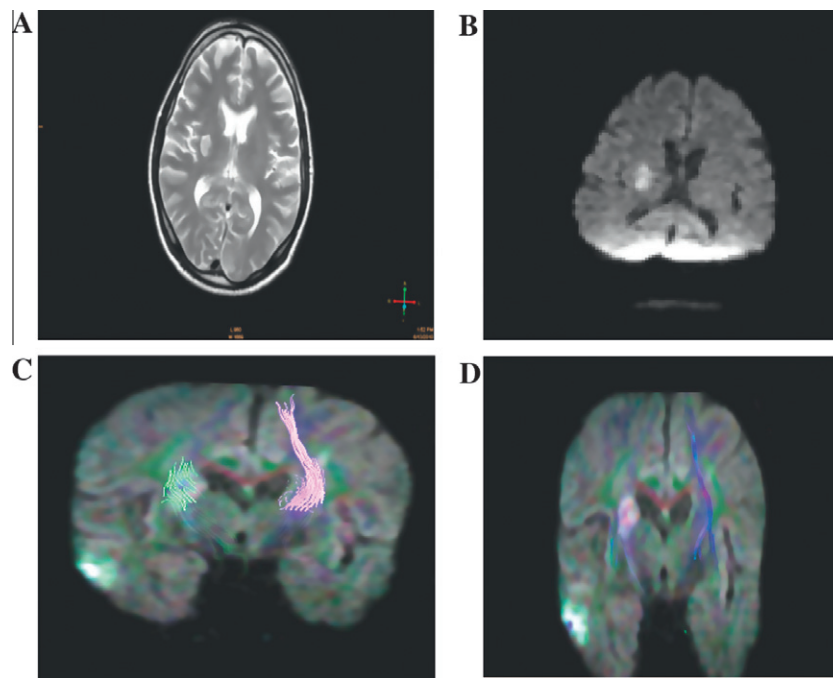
Patient # 2 presented with left sided weakness. (A and B) Axial T2 weighted and DWI image displaying a hyperintense zone of an early subacute infarction in the posterior limb of the right internal capsule. (C and D) The DTT colored images superimposed on the coronal DWI showing total disruption of the pyramidal tract fibers of the affected right side in comparison to the contralateral healthy side associated with poor motor outcome of this patient.
